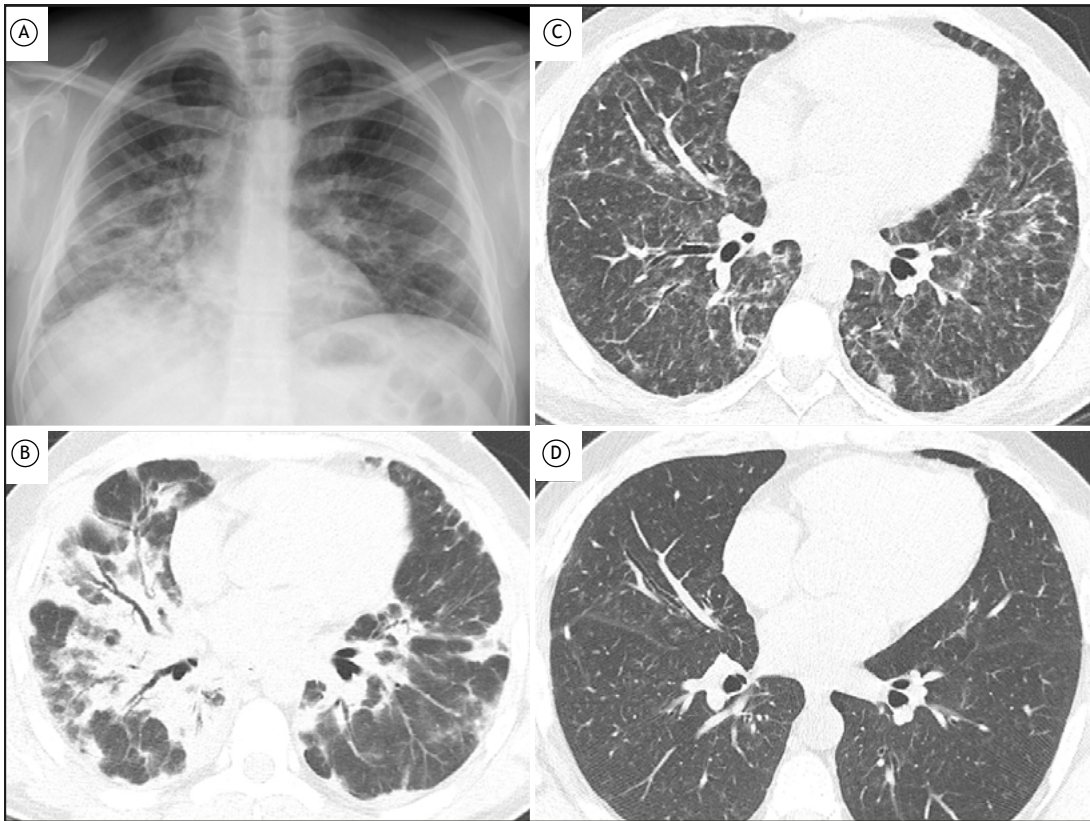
In A, chest X-ray showing bilateral alveolar opacities. In B, chest CT angiographic image showing multifocal consolidations with a peribronchial component. In C, chest HRCT scan showing improvement of consolidations, with persistent areas of mosaic and ground-glass pattern. In D, 6-month HRCT scan showing complete resolution of the previous consolidation and patchy areas of ground-glass opacity.
